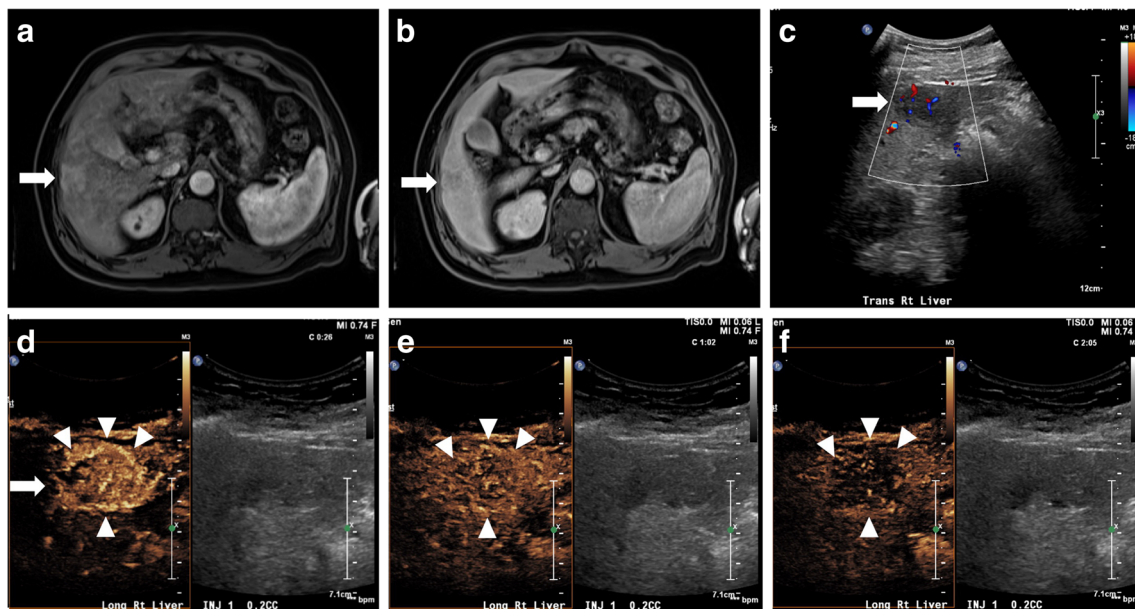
a, b Patient with unknown history of liver disease presented with an indeterminate liver lesion on MR (*arrow*). c Color Doppler US of the same lesion in a and b, showing a hypervascular and hypoechoic lesion (*arrow*). d Dual display of microbubble-only image (*left hand panel*) and B-mode image (*right hand panel*) shows rapid arterial enhancement 26 s
